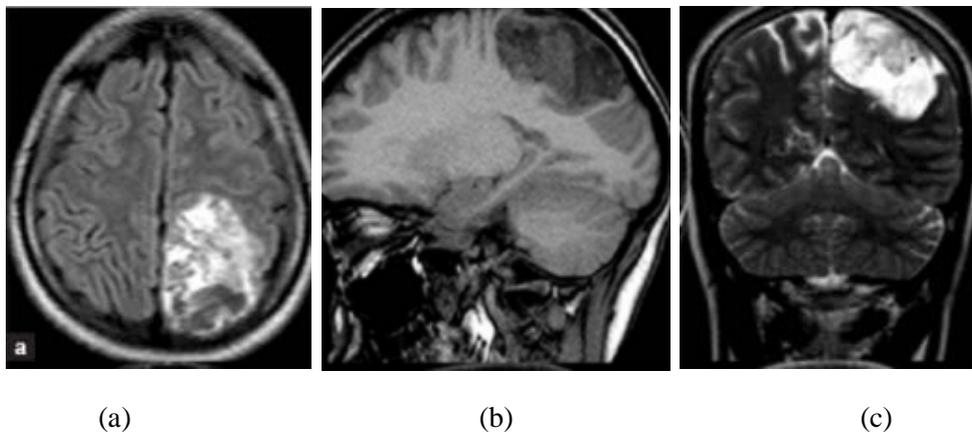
shows MRI views in three planes a) Axial (b) Sagittal (c) Coronal
